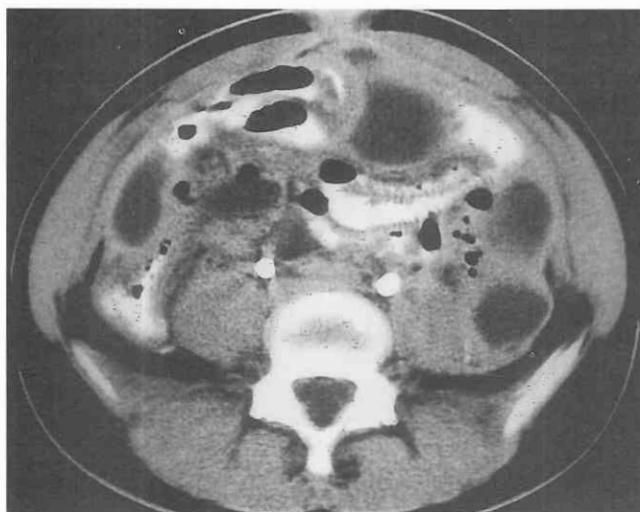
Ruptured appendix. CT scan through the lower abdomen in a patient with a ruptured appendix demonstrates multiple rounded, low-attenuation interloop collections representing multiple abscesses.
